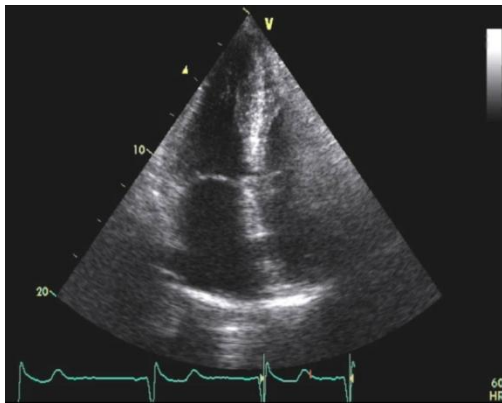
4 chamber 2D echocardiographic view, in the Mayo format (with left sided structures to the left of the picture), showing apical hypertrophy with possible apical pouch.
